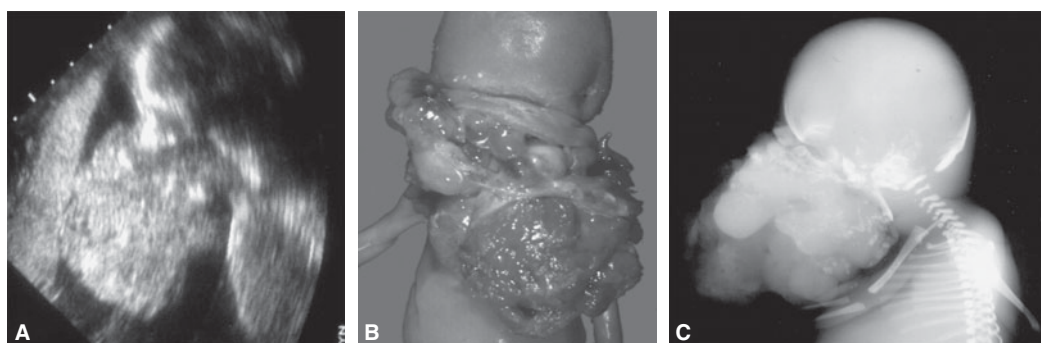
Epignathus. (A) Antenatal sonogram. (B) Postnatal image. (C) Postnatal radiogram. (B, C courtesy of Frank Chervenak, MD.)
